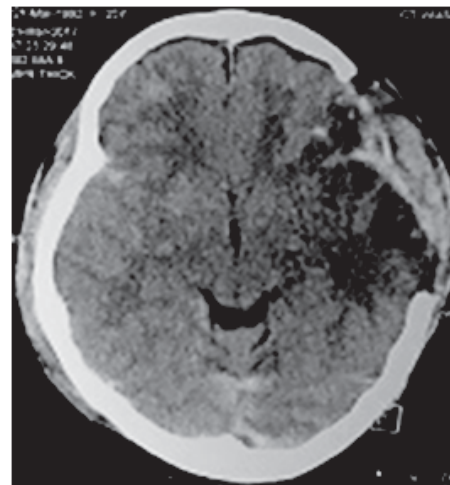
CT scan of head on 3<sup>rd</sup> POD
